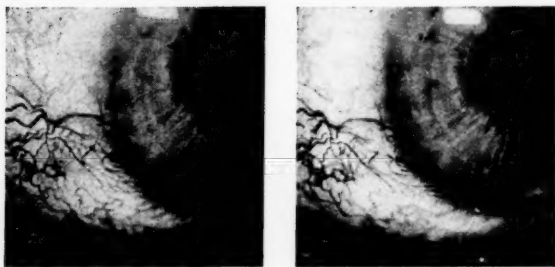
(Vail and Ascher). Stereophoto of the left lower nasal concentric collateral of Myrtle B., a white woman, aged 42 years.* The collateral covers almost the whole quadrant. The diagnosis of the Nutrition Clinic was riboflavin deficiency. The patient gave a history of "red eyes" since childhood, of burning, watering, photophobia, and hemeralopia for many years. Her diet was very high in food containing vitamin B. She had been taking vitamin-B preparations for many months. Her mother died of tuberculosis. The patient had not had any serious disease since 1925, at which time an appendectomy was performed. X-ray examination of her chest gave evidence of "old lesions." There was papillary hypertrophy in her tarsal conjunctivas, slight injection of the latter as well as of the fornices and semilunar folds. Pingueculas were present in the nasal conjunctiva of both bulbi, and hyaline and calcareous deposits in both bulbar conjunctivas. In July she developed cheilosis of both angles.
